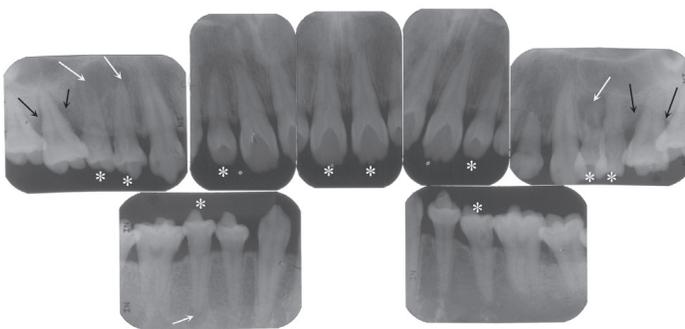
Periapical radiographs demonstrated ten dens invaginatus (*), four apical radiolucencies (white arrows) and severe vertical bone loss at the upper right and left first molars (black arrows)
